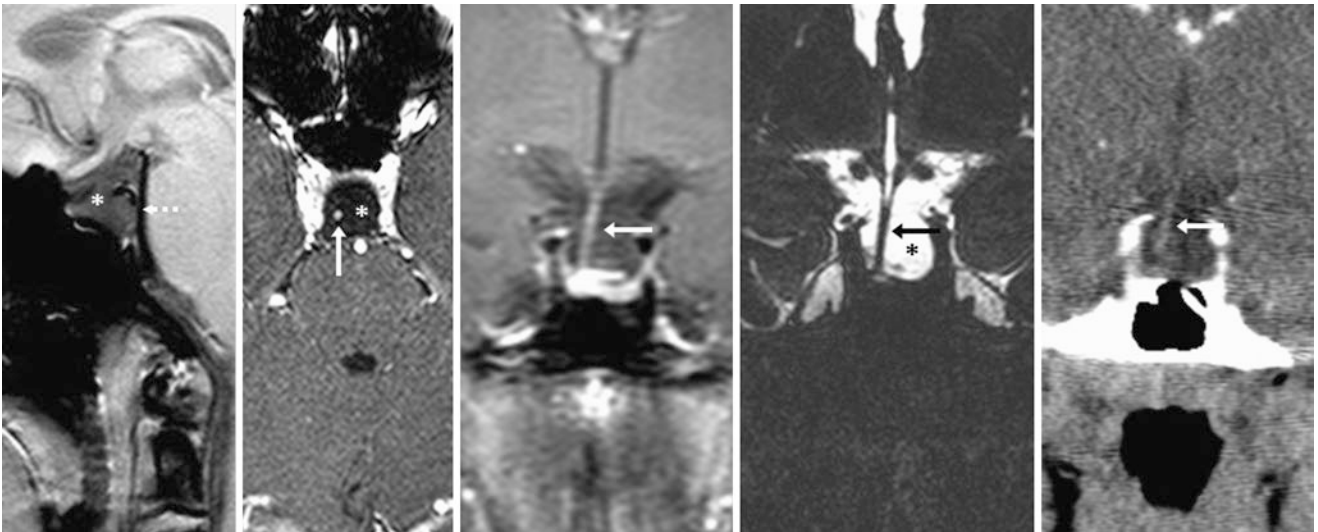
A 45-year-old female patient was seen with otalgia and neck pain. A complete form of PES (*) was found incidentally with a moderately enlarged sella on a cervical 3 T MRI. Note the thin posterior wall of the sella (*dashed arrow*) on noncontrast sagittal T1WI (*left*).
